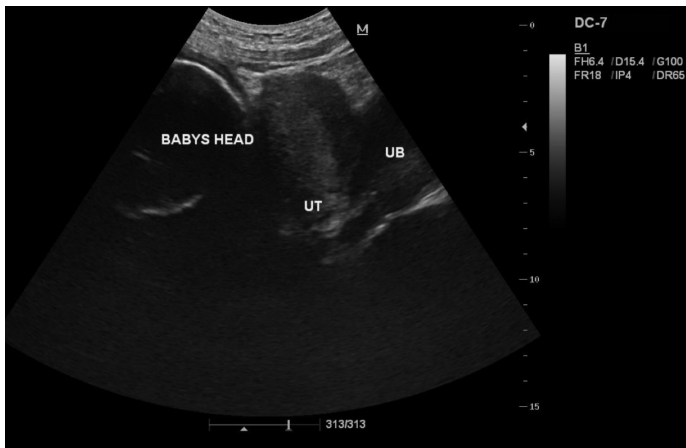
Transvaginal Ultrasound showing the empty uterus alongside the fetal head.
